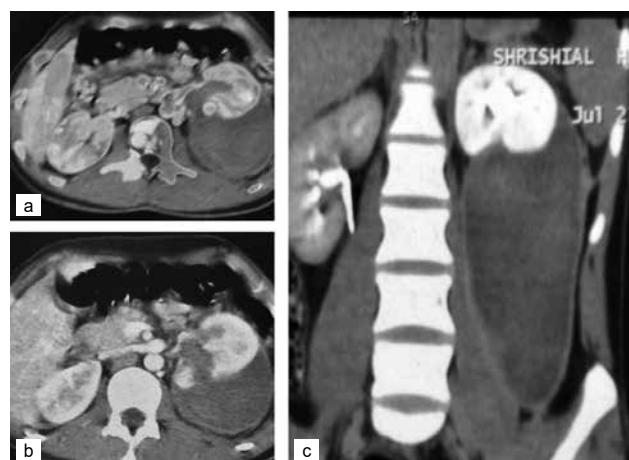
(a) CT scan showing a huge perirenal collection. (b) scan showing lower polar laceration communicating with renal pelvis. (c) CT scan showing a huge perirenal collection trickling down the fascia of Gerota.
